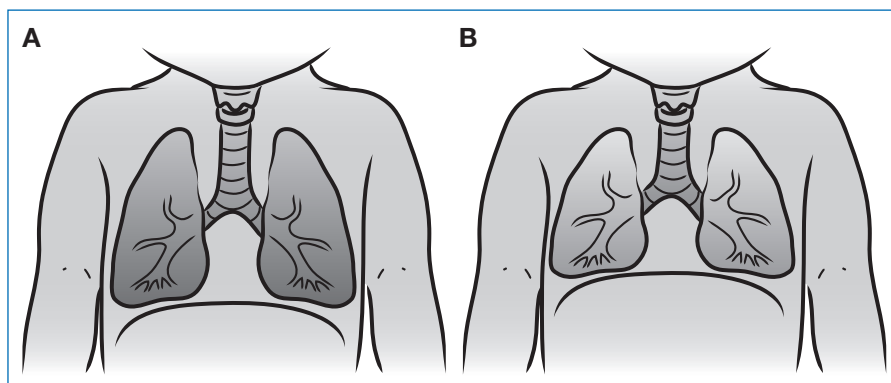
Differences in appearance between inspiration (A) and expiration (B) in a neonatal chest radiograph. On full inspiration, the diaphragm is located at the eighth rib, and the lungs appear larger and darker. During expiration, the diaphragm is at or above the seventh rib, and the lung fields appear smaller and lighter. The heart size may also appear larger on expiratory films.
